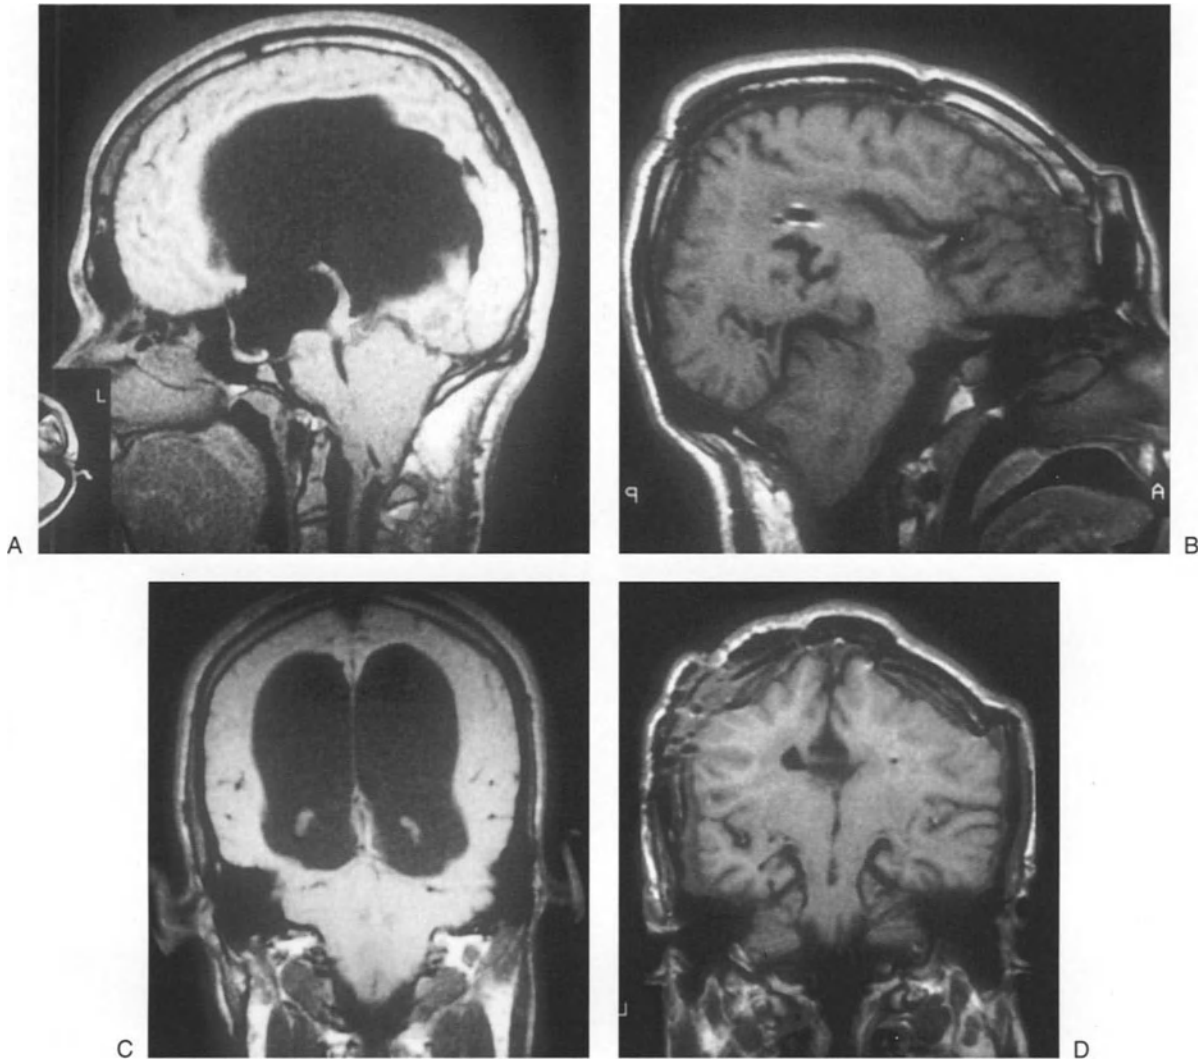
(*continued*). Consequently, we have not found that there is any single surgical procedure which may resolve all the problems encountered, nor that there is a single sequence of surgical procedures which may be used. Rather, each child is treated step by step, as problems arise; each adolescent presents different craniocerebral and vertebromedullary problems. (A) This is a 19-year-old boy whose meningo-myelocele was repaired at birth and who then carried a ventriculojugular shunt until 16 years of age, suffering all of its complications: repeated failures, shunt nephritis, septic endocarditis, occlusion of both internal cerebral veins and subsequent porta-portal transthoracic collateral flow, etc. The biventricular hydrocephalus, III ventricle almost within the sella turcica, beaking of the midbrain, linear transformation of the IV ventricle, herniation of cerebellum, and medulla oblongata into the cervical cord are all visible. (B) After a suboccipital craniectomy, resection of the arch of C1, resection of the tonsils and opening of the vallecule and foramen magnum, and fascia lata duroplasty creating a pseudocisterna magna, the operation was performed. The boy improved for a few days and then suffered massive bilateral subdural hematomata from
